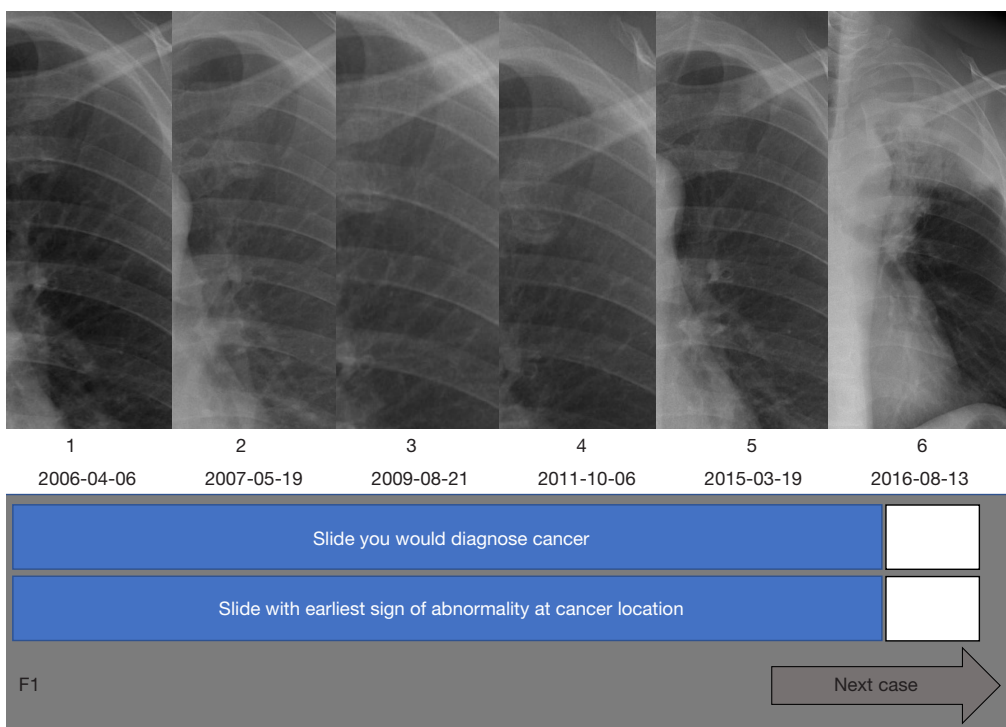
A sample screen of cropped side-by-side images of CXRs viewed by participants. CXR, chest radiography.
